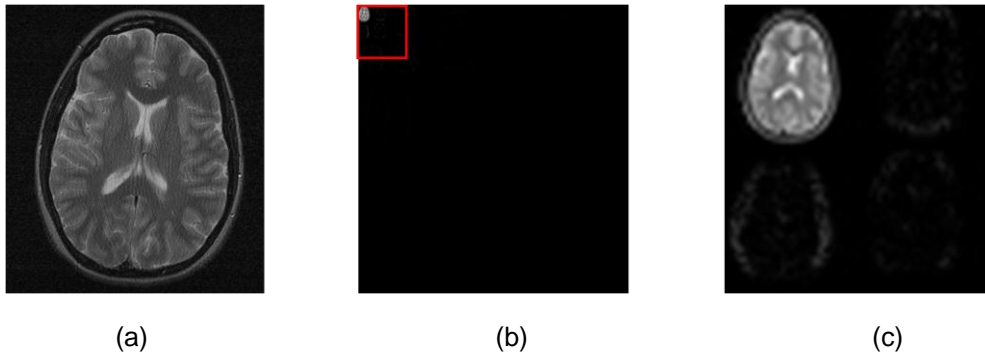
Transform sparsity: (a) A 2D MR image of the human brain (b) Representation of the object in 2D Daubechies wavelet transform domain (c) A magnified view of the wavelet coefficients shown in the red square in (b)
